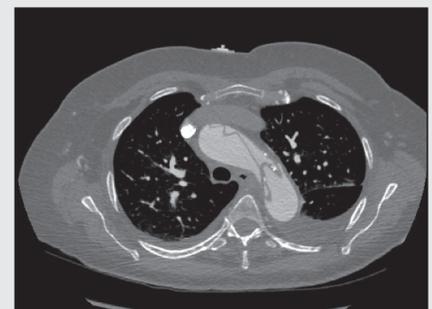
CT angiography demonstrates complex aortic dissection involving the aortic arch.
